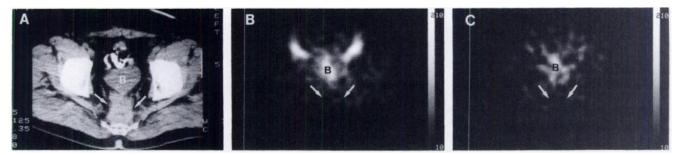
(A) CT (transaxial slice) image shows an extensive hyperdense lesion in the pre-sacral area 2 yr after rectum surgery (B = bladder activity). (B) Anti-CEA immuno SPECT (transaxial slice 6 hr postinjection). There is no antibody accumulation in the presacral area (B = bladder activity). Immunoscintigraphy gave evidence that the extensive hyperdense TCT lesion might be scar tissue after surgery; computer-assisted biopsy confirmed the diagnosis of "scar tissue." (C) Anti-CEA immuno SPECT (transaxial slice 24 hr postinjection). There is no antibody accumulation in the pre-sacral area.
